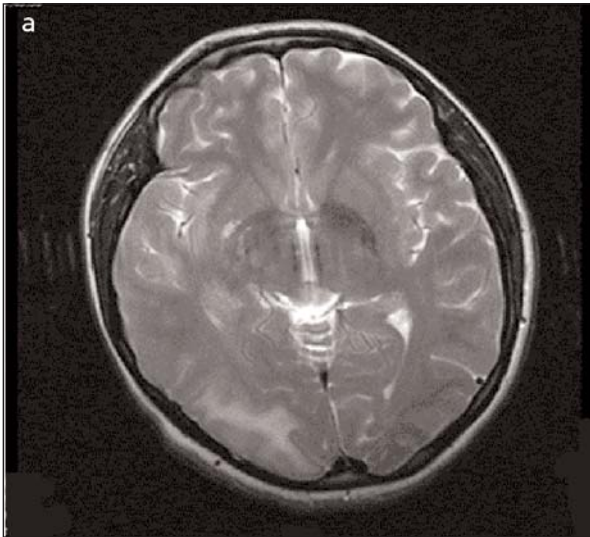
T2 weighted images in brain MRI of the patient with SSPE revealed hyperintense lesions bilaterally in the posterior areas but prominent on the right occipital lobe, mostly involving white matter.
